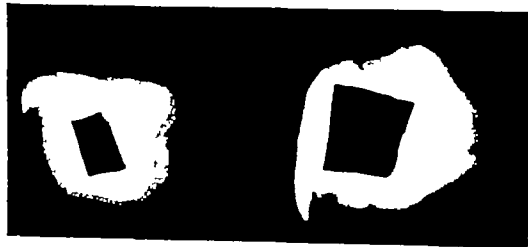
Radiographs of two radium molds to show the relative radiodensity
